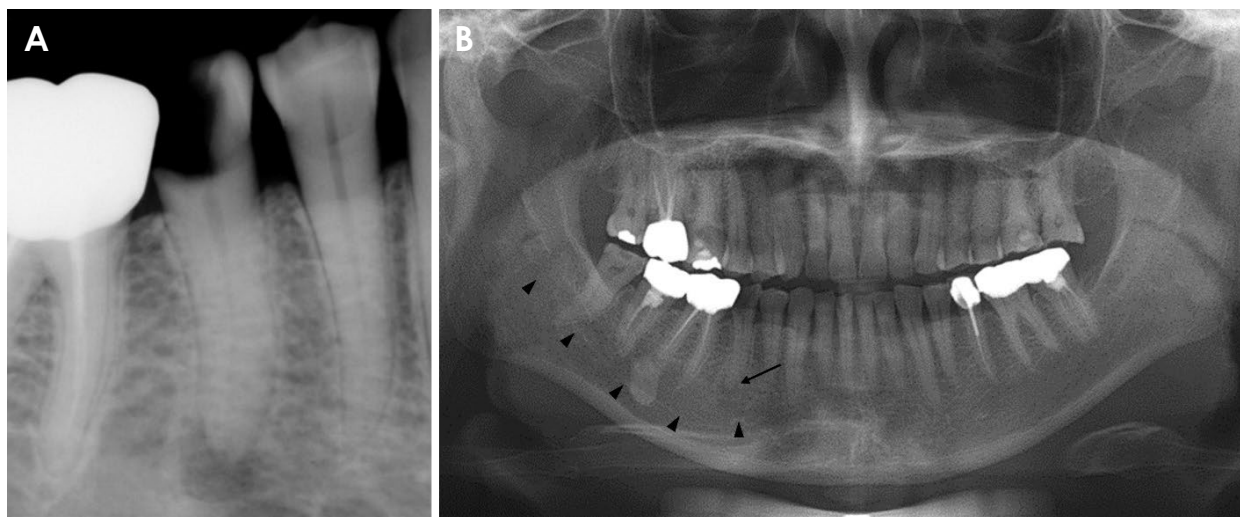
A. A periapical radiograph reveals severe dental caries and periapical rarefaction of the right mandibular second premolar. B. A panoramic radiograph displays a suspected close relationship between the periapical lesion (indicated by the arrow) and the anterior loop of the inferior alveolar nerve (marked by arrowheads).
